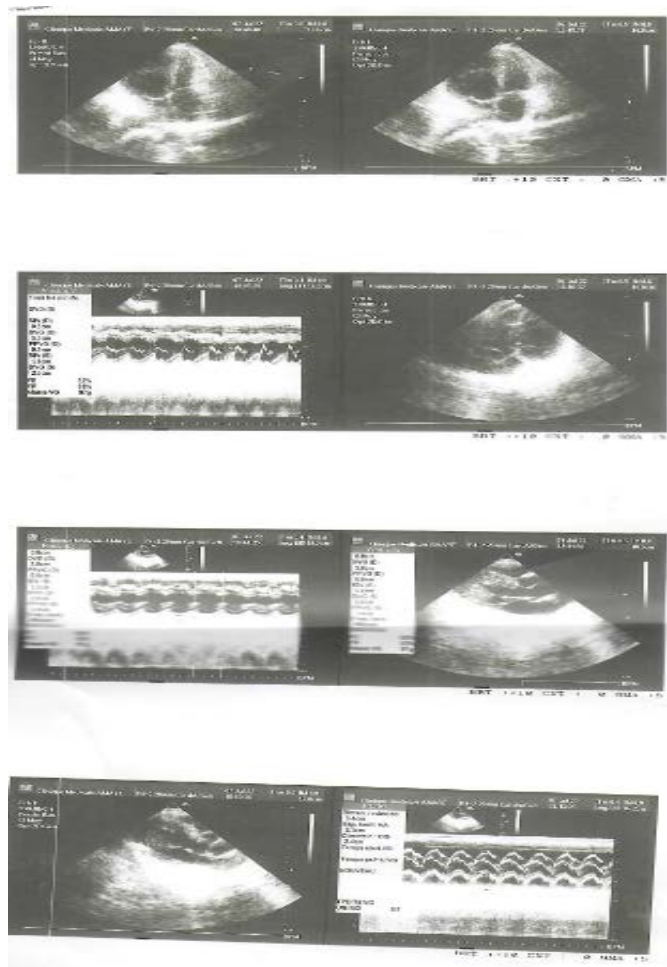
Cardiac ultrasound.
